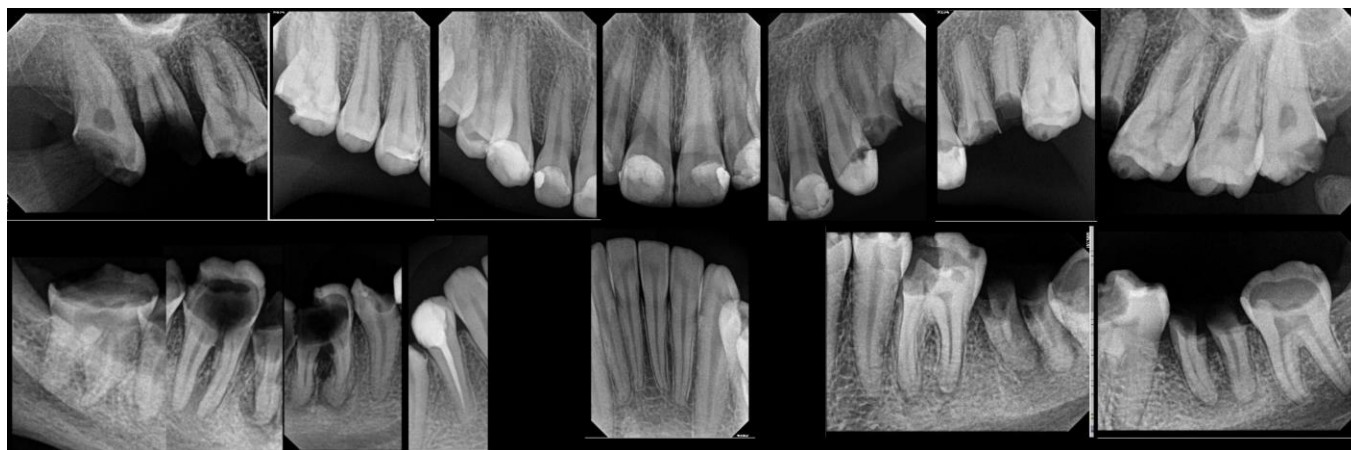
preoperative periapical radiographical views
